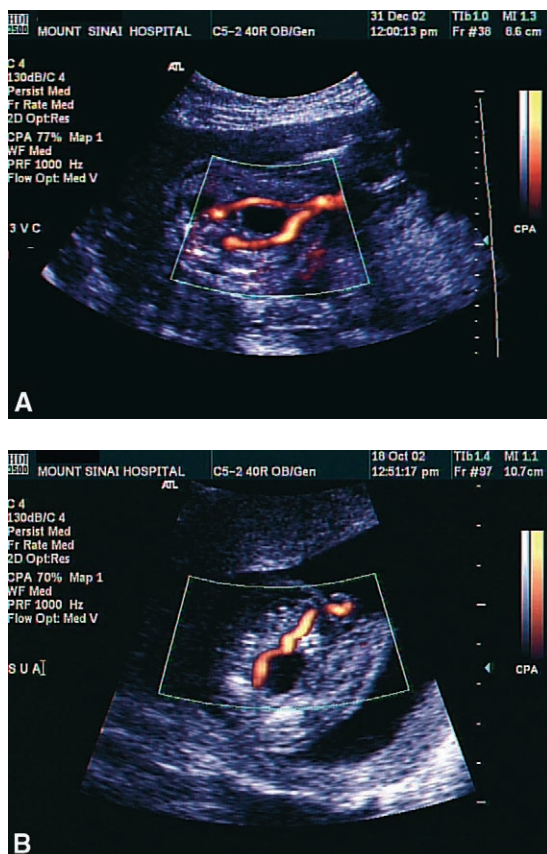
Umbilical arteries as seen on color Doppler in the area of the fetal abdominal cord insertion site. (A) Normal appearance of two umbilical arteries as they course around the fetal bladder. (B) Single umbilical artery. Only one artery is seen going around the bladder.
